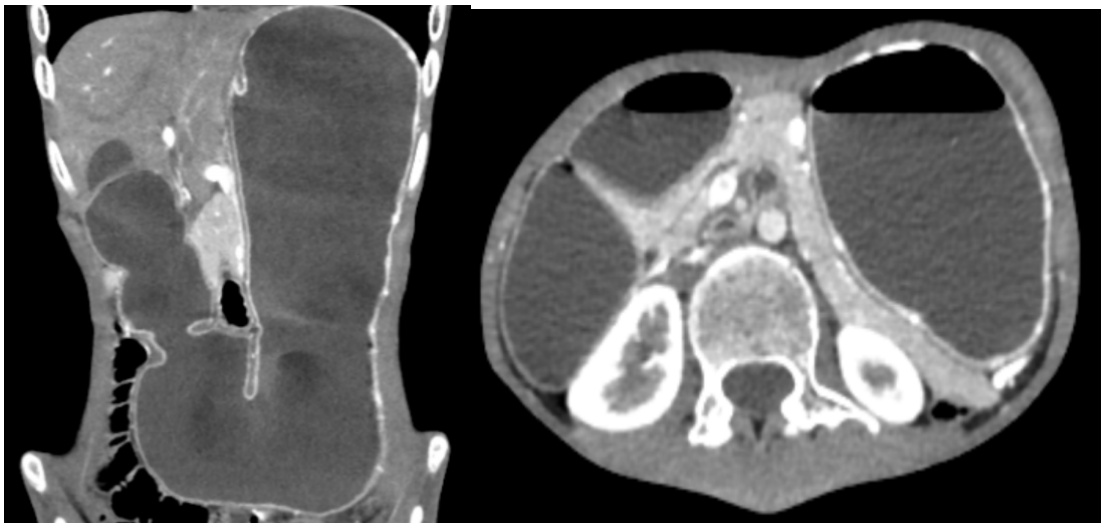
Coronal CT image showing grossly dilated stomach and duodenum
